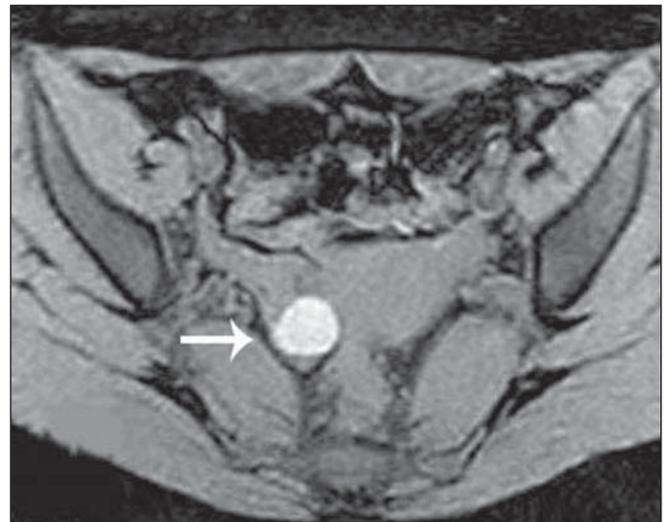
Endometrioma. Axial MRI T1-weighted water-image acquired with a 0.2 T scanner, demonstrating a focus of hypersignal intensity on the right ovary.
